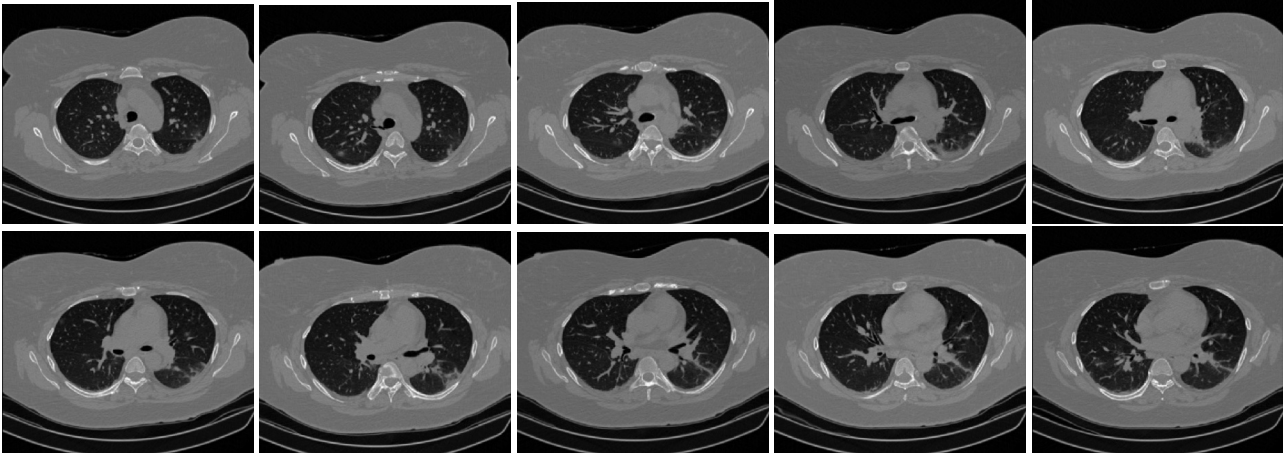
Slices from a COVID-19 case in COV19-CT-DB
